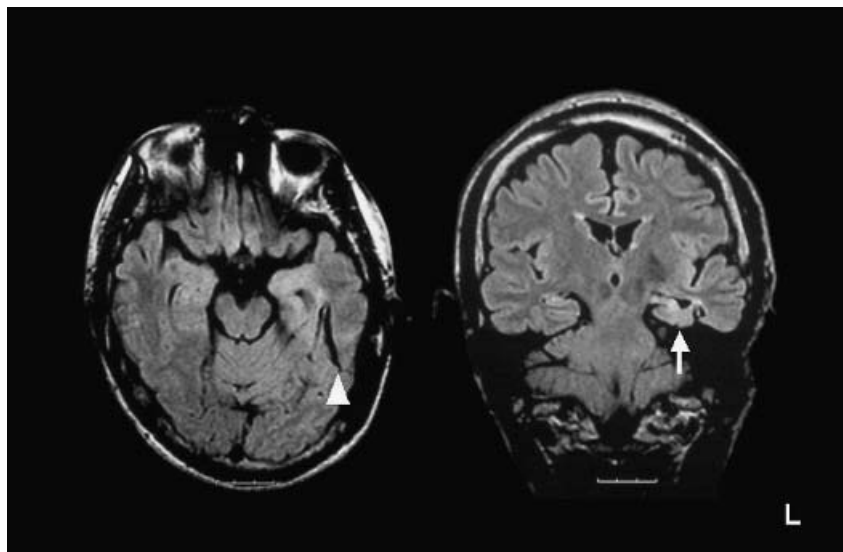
Head magnetic resonance imaging scan of this patient showing the left hippocampal atrophy (arrow) and a streak cavity in the left mid-to-posterior temporal region (arrowhead).
